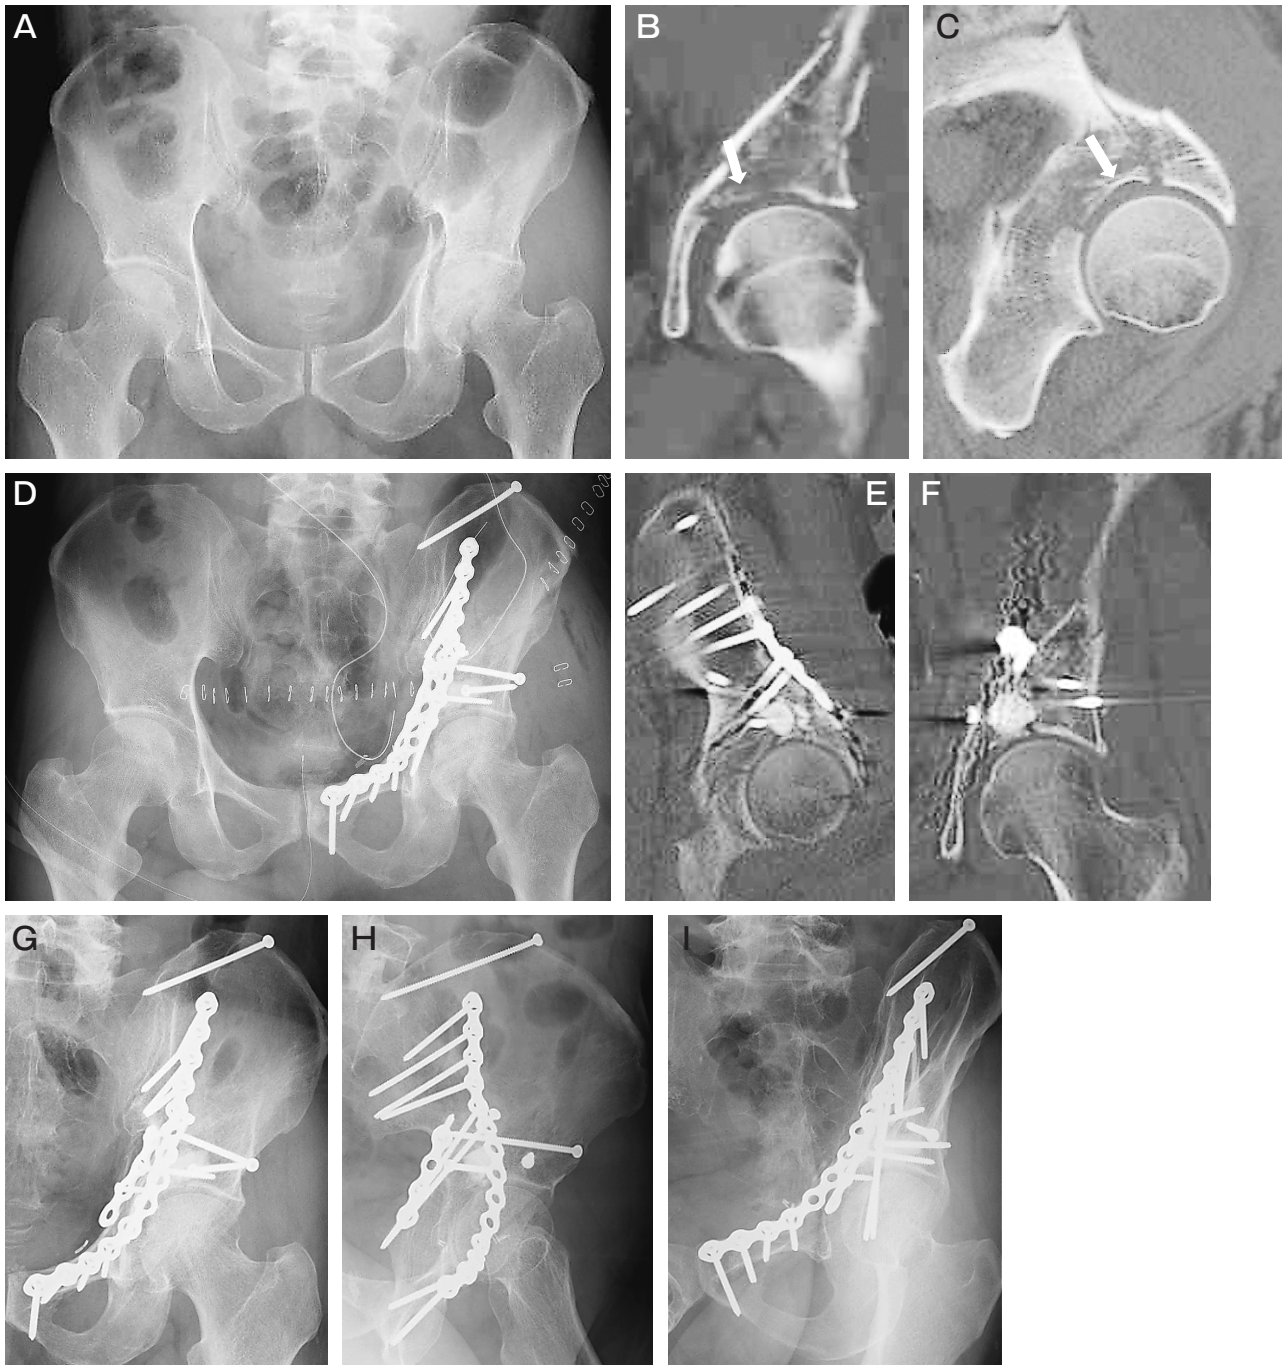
Images of the clinical course in the left hip joint of a 70-year-old man who sustained a both column acetabular fracture. A, An anteroposterior radiograph at the injury; B,C, CT images at the injury showed a roof impaction (RI) fragment on the weight-bearing surface (*white arrow*); D, An anteroposterior radiograph after surgery showed a weight-bearing surface anatomically fixed using the modified Stoppa approach combined with the lateral-window of the ilioinguinal approach; E,F, CT images after surgery showed an anatomical reduction on the weight-bearing surface; G-I, Radiographs at 3 years post-surgery showed no sign of joint-space narrowing. The Matta clinical score was 18, and the outcome was graded as excellent.
